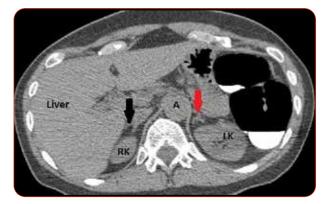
Axial CT scan showing right kidney (RK), left kidney (LK), left renal vein (red arrow), and renal artery (yellow arrow).
